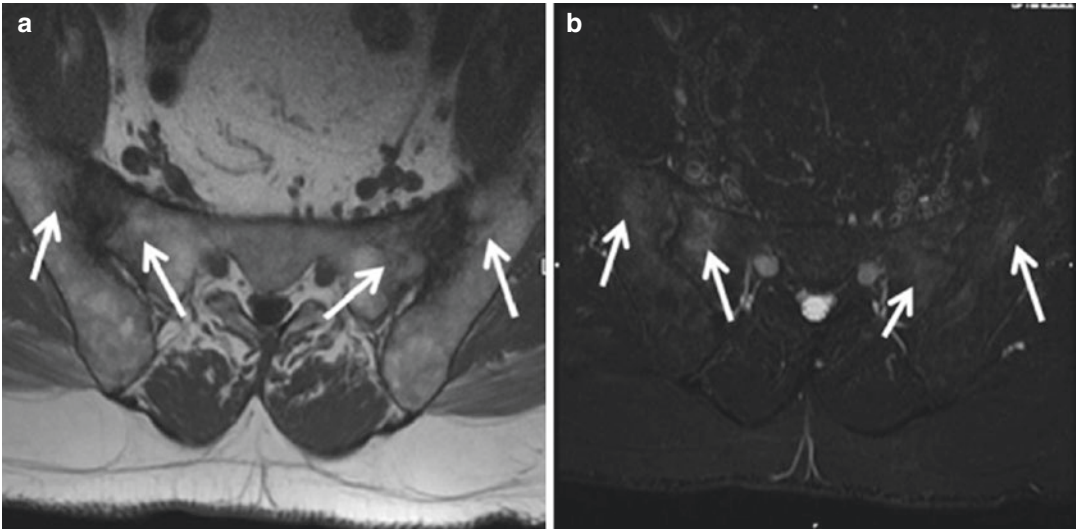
A 58-year-old with AS. Axial (a) T1-weighted and (b) T2-weighted, fat-saturated MRI demonstrate symmetric, subarticular, bone marrow edema-like signal (dark
